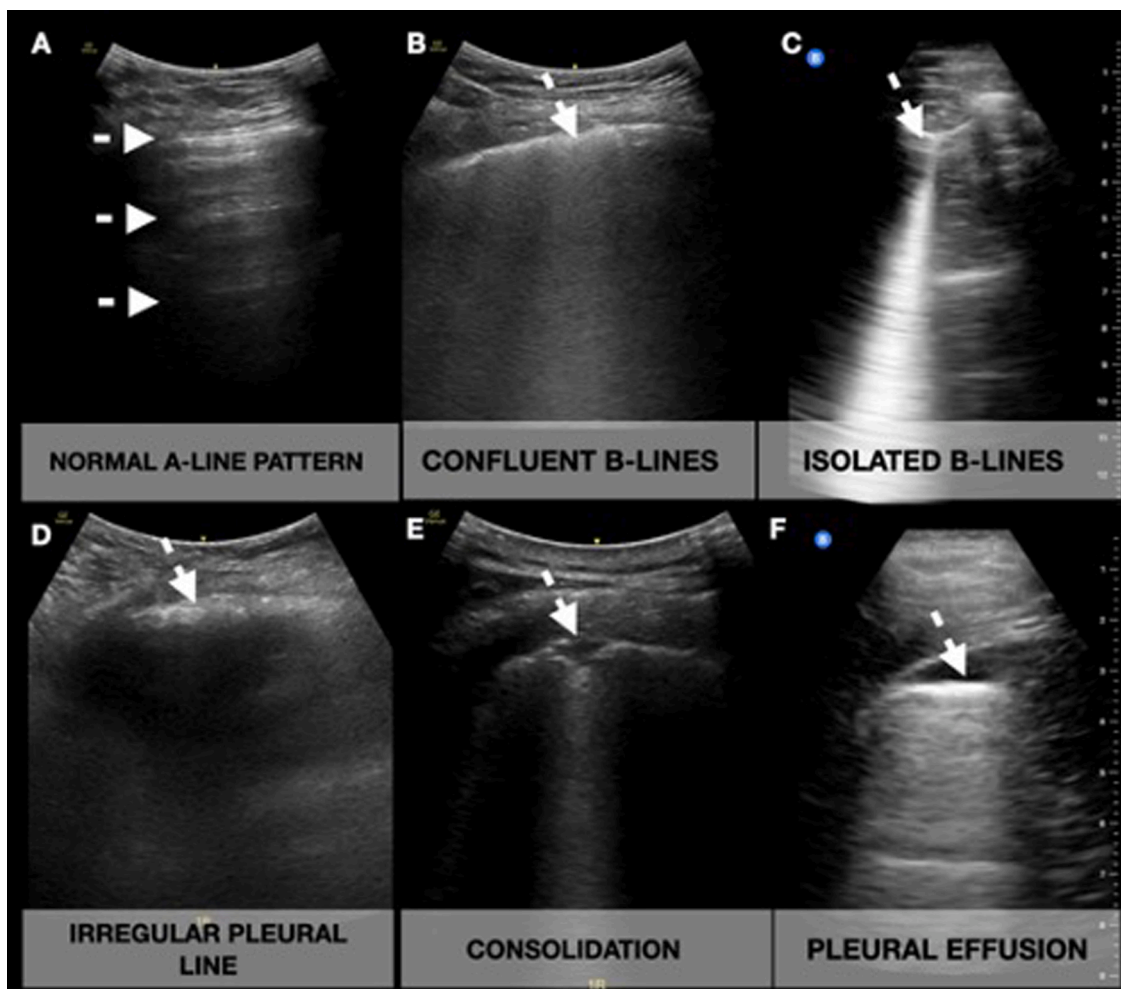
Lung ultrasound patterns in patients with Covid-19 pneumonia.
